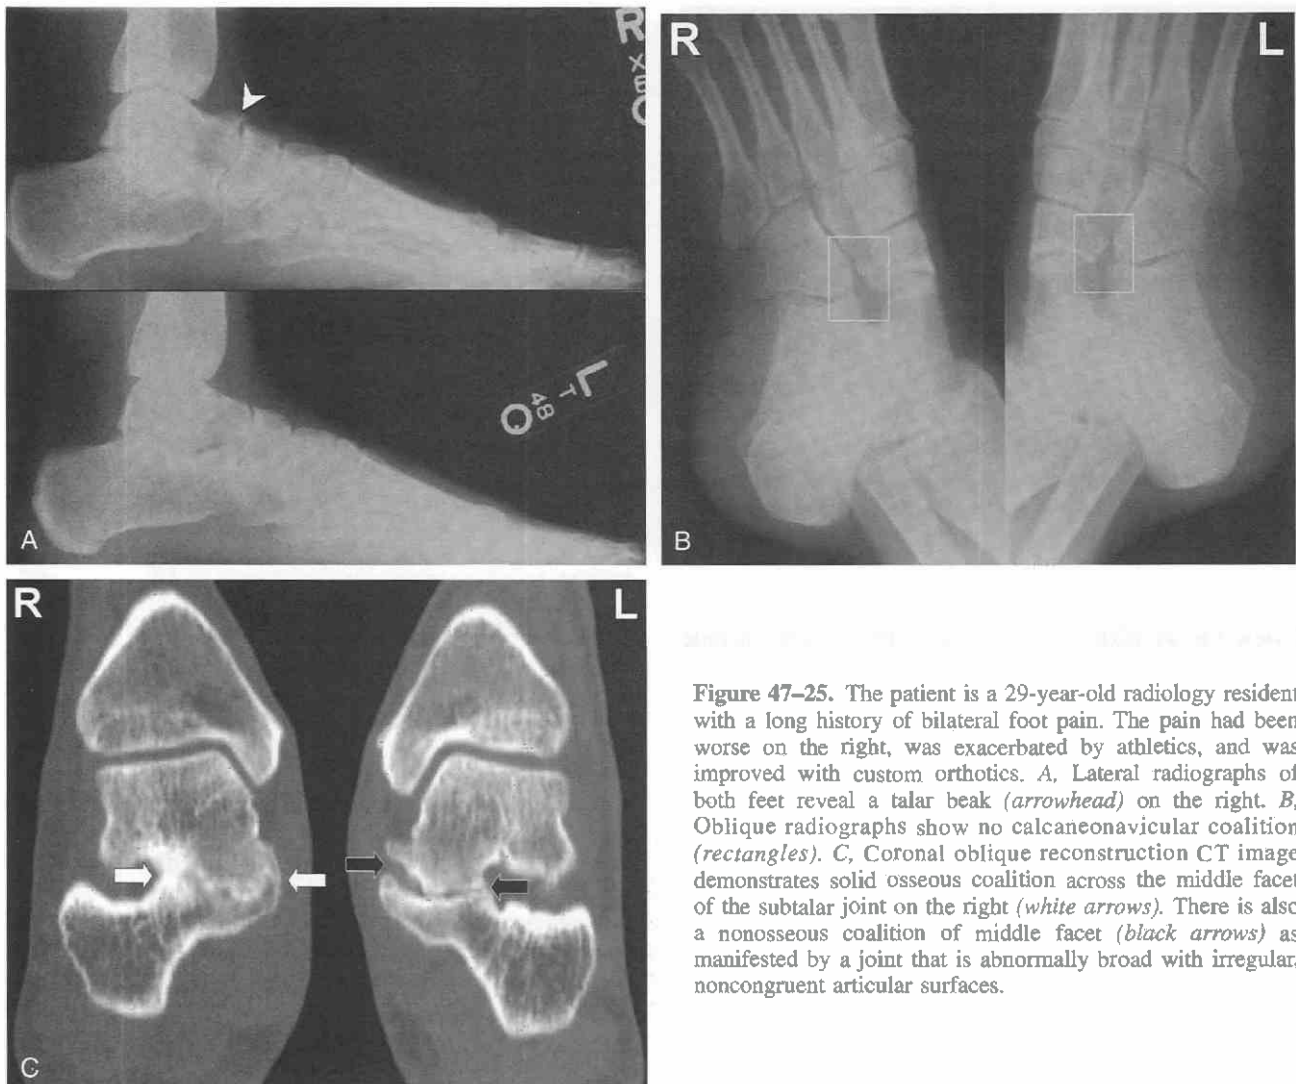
The patient is a 29-year-old radiology resident with a long history of bilateral foot pain. The pain had been worse on the right, was exacerbated by athletics, and was improved with custom orthotics. *A*, Lateral radiographs of both feet reveal a talar beak (*arrowhead*). *B*, Oblique radiographs show no calcaneonavicular coalition (*rectangles*). *C*, Coronal oblique reconstruction CT image demonstrates solid osseous coalition across the middle facet of the subtalar joint on the right (*white arrows*). There is also a nonosseous coalition of middle facet (*black arrows*) as manifested by a joint that is abnormally broad with irregular, noncongruent articular surfaces.
